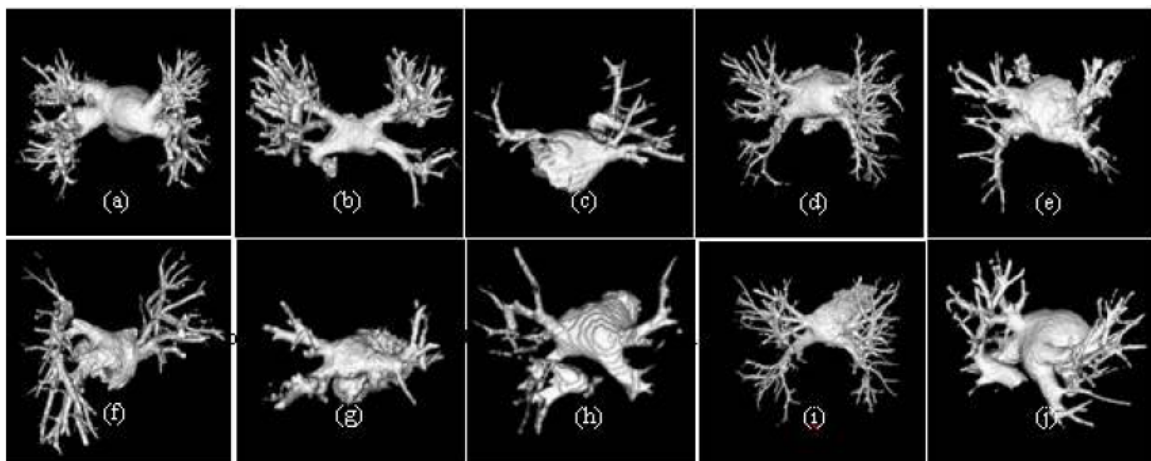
Surface reconstructions of the left atrium from contrast-enhanced MR images. Note the variations between different patient subjects
